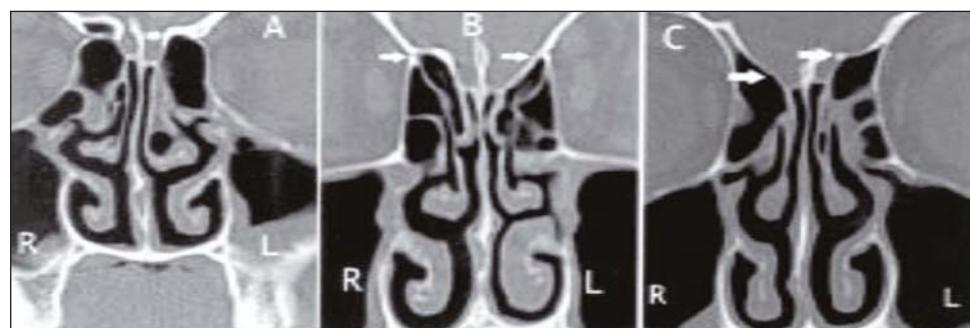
Coronal sinus CT scan showing three patterns of ethmoid asymmetry with A) height asymmetry with low lying fovea on left (arrow), B) contour asymmetry with flattening of fovea on left side (arrows) and C) combined height and contour asymmetry (arrows)
